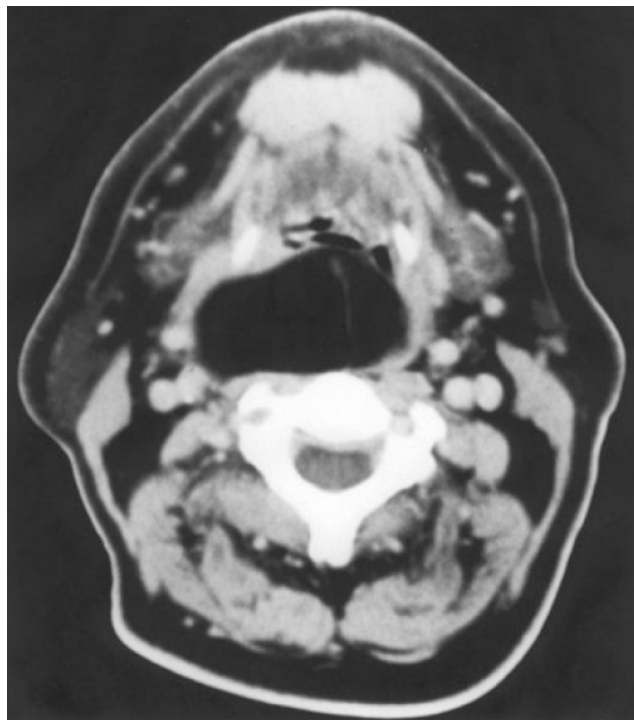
Axial computed tomography scan reveals a lipoma involving the parapharyngeal and retropharyngeal space.
